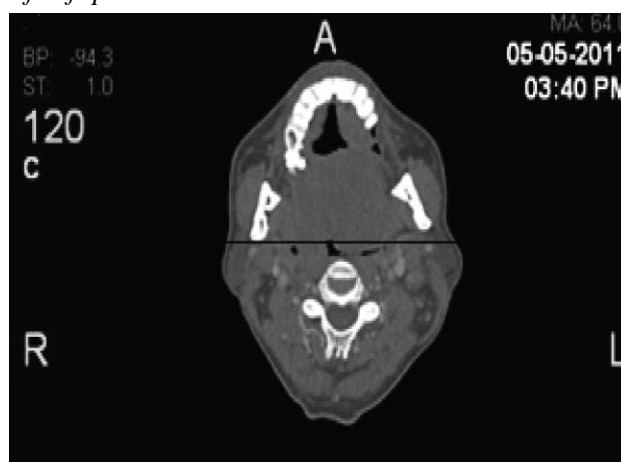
Axial view CT scan of oral cavity showing the tumour mass occupying the oropharynx (Arrow) with minimal residual airway.
